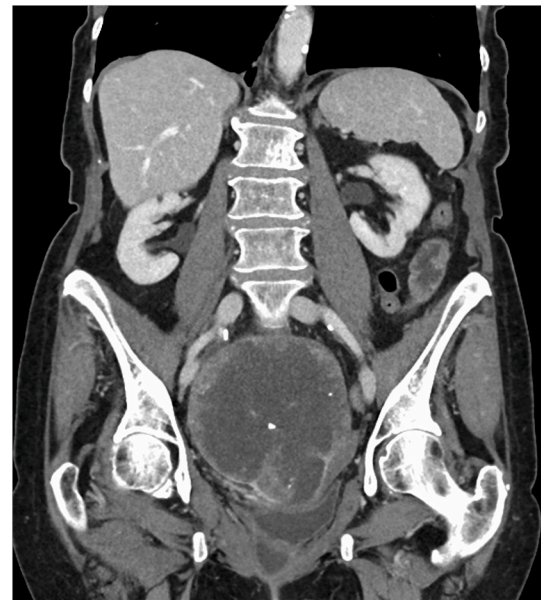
Contrast-enhanced pelvic computed tomography scan showing a large necrotic pelvic mass with coarse calcifications.
